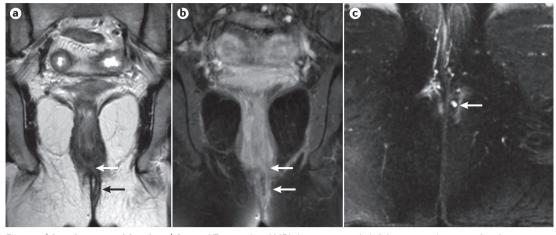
Simple perianal fistula. a | Coronal T2-weighted MRI showing a single left low intersphincteric fistula (arrows) with a single external opening and without extensions or associated collection. b | Coronal gadolinium-enhanced T1 sequence with fat saturation showing the enhancement of the fistula track (arrows). c | Depicts the same fistula from (part a) and (part b) on axial T2-weighted imaging with fat saturation, showing marked signal intensity (arrow). The rectal wall (not seen) was normal on MRI. The total van Assche MRI activity score was 10.
